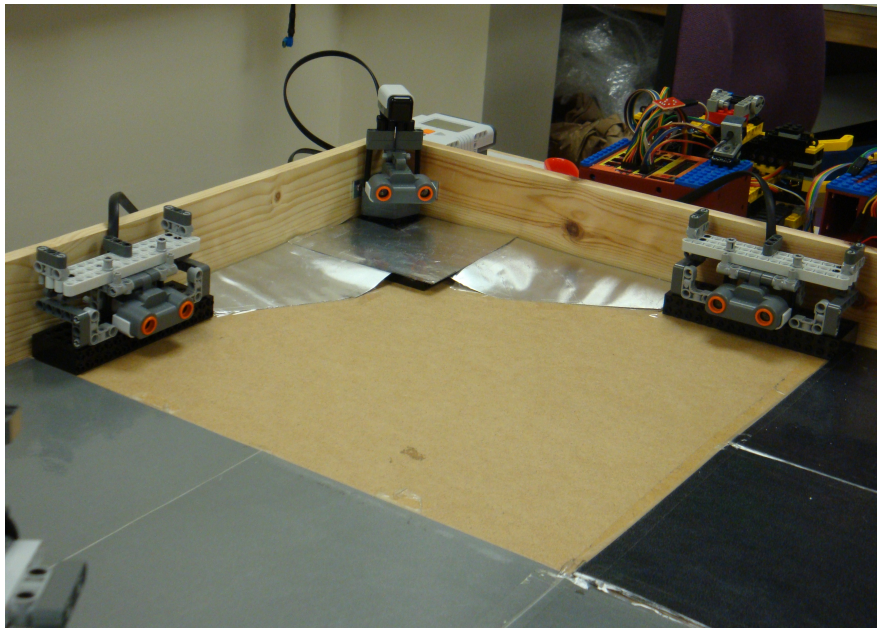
Our robotic nest: designed to add a further dynamic to the environment of our developed animats. This consisted of a LEGO NXT, with ultrasonic sensors fitted to deter the predator from the area, as well as to allow the prey to detect and “home in” to its nest from a (small) distance away.
